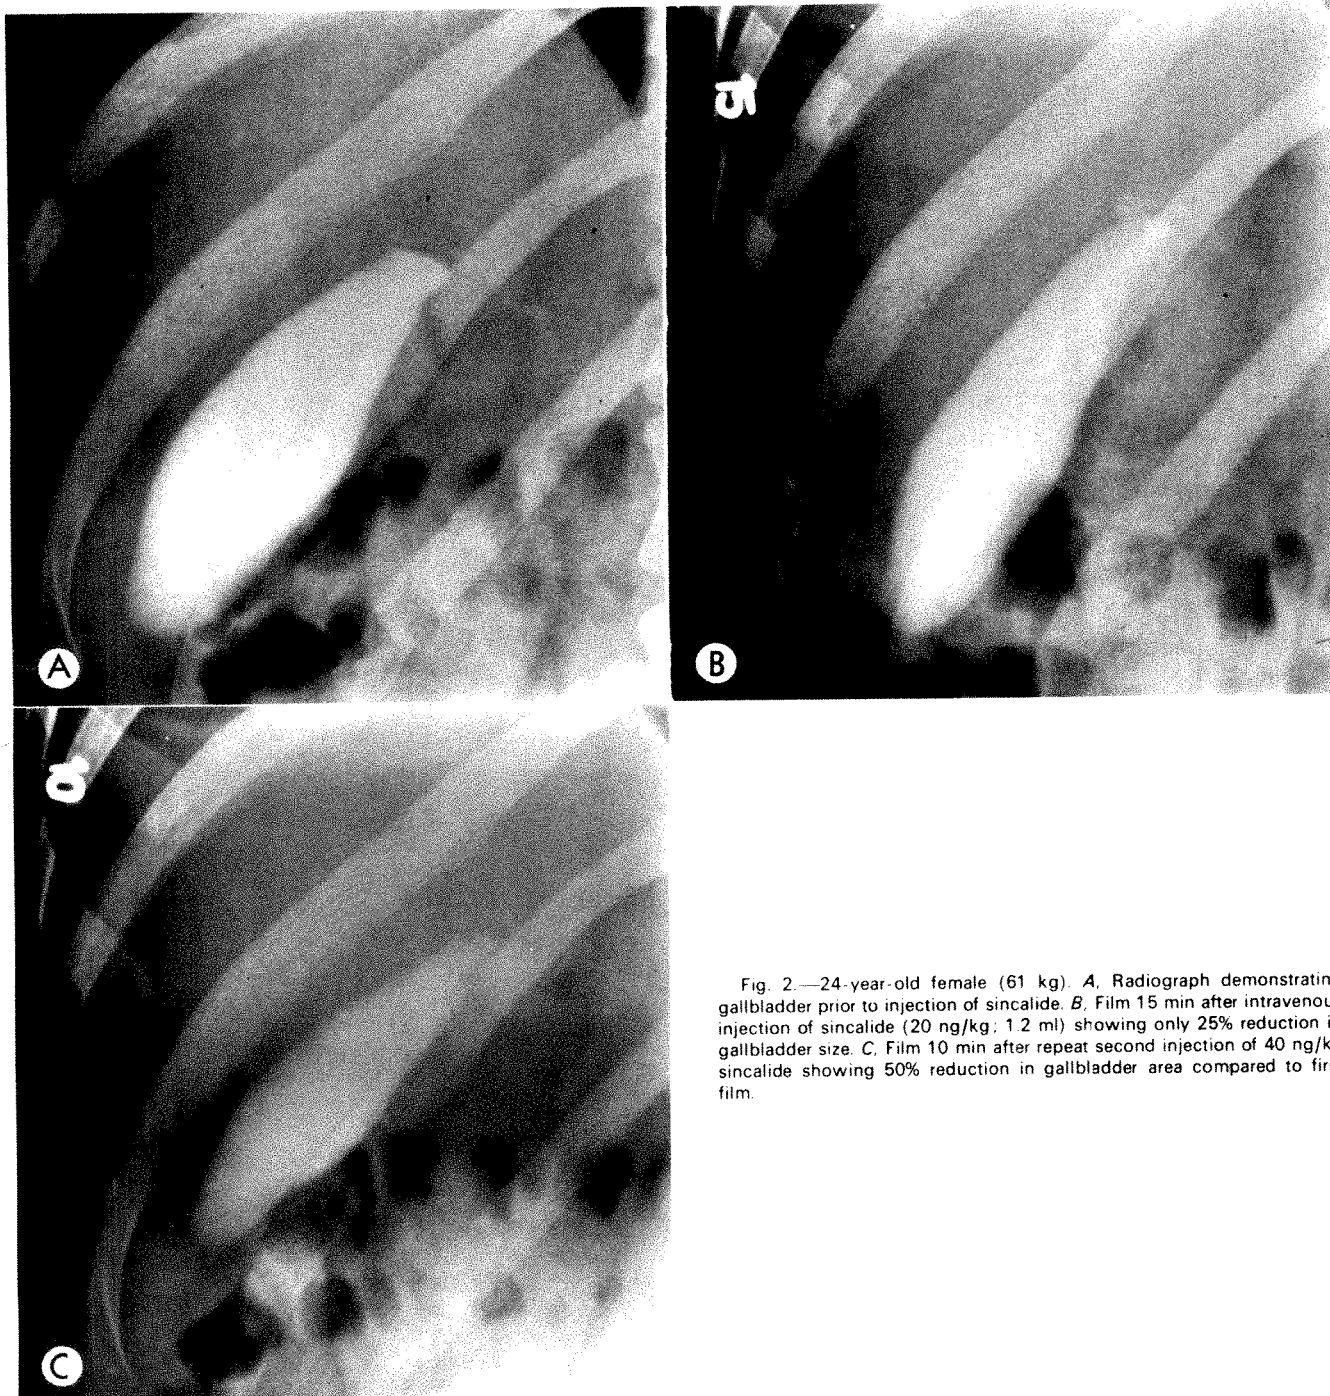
24-year-old female (61 kg). A, Radiograph demonstrating gallbladder prior to injection of sincalide. B, Film 15 min after intravenous injection of sincalide (20 ng/kg; 1.2 ml) showing only 25% reduction in gallbladder size. C, Film 10 min after repeat second injection of 40 ng/kg sincalide showing 50% reduction in gallbladder area compared to first film.
